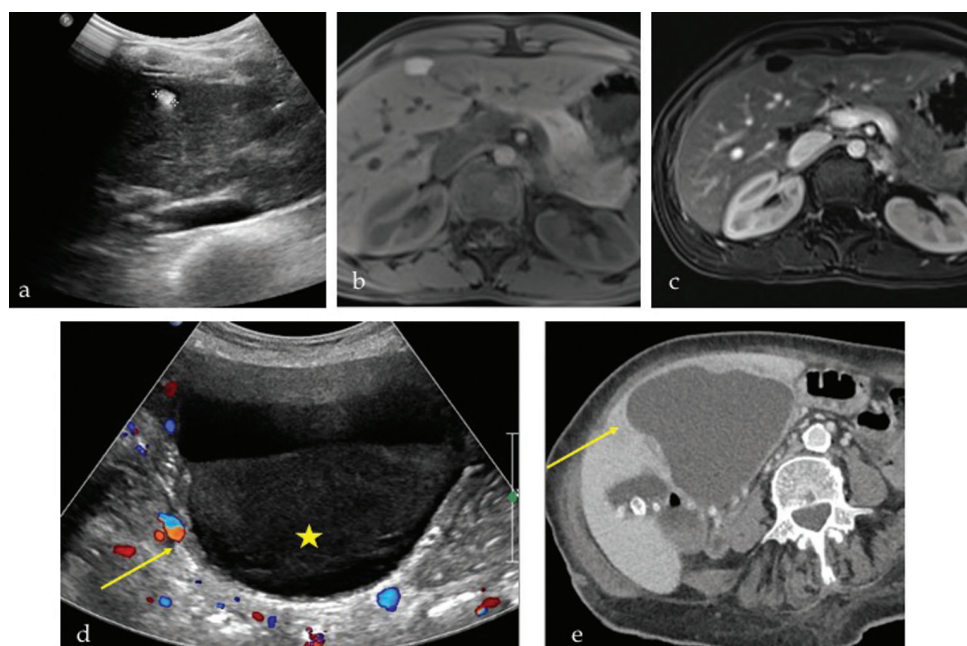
Haemorrhagic cyst on (a) ultrasound, (b) pre-contrast T1W magnetic resonance imaging and (c) post-contrast T1W magnetic resonance imaging. It is echogenic on ultrasound, T1 bright and shows no enhancement. Infected cyst on (d) ultrasound and (e) postcontrast computed tomography. Note thick, enhancing wall and internal debris (star).
